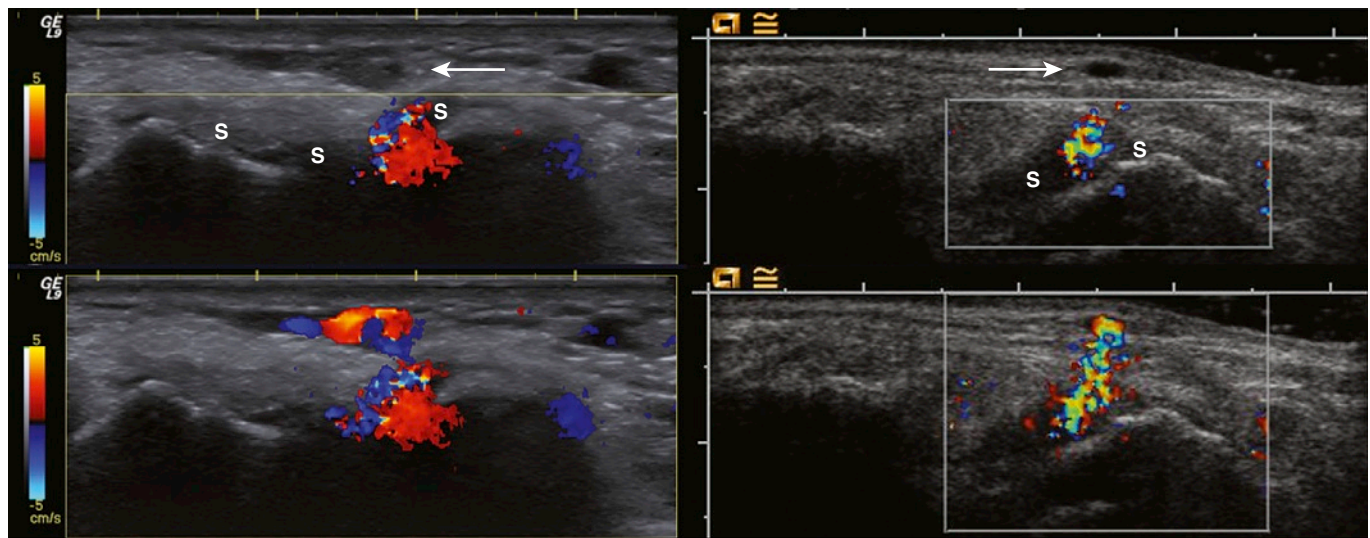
REVERBERATION. The images demonstrate the importance of letting the Doppler box extend to the top of the image. (Top) The color box does not cover the most superficial part of the image, where the superficial veins (arrows) are located. The synovium (S) is hyperemic. (Bottom) The color boxes extend to the skin surface and include the superficial veins. The color Doppler activity in the synovium is reverberation from the superficial veins. Left, Images were produced with a General Electric L9 with M12 transducer. Images (right) were produced with a Siemens Acuson Sequoia with a 15L8W transducer. (From Torp-Pedersen S, Terslev L: *Settings and artefacts relevant in colour/power Doppler ultrasound in rheumatology*. *Ann Rheum Dis* 2008;67:143-149.)
